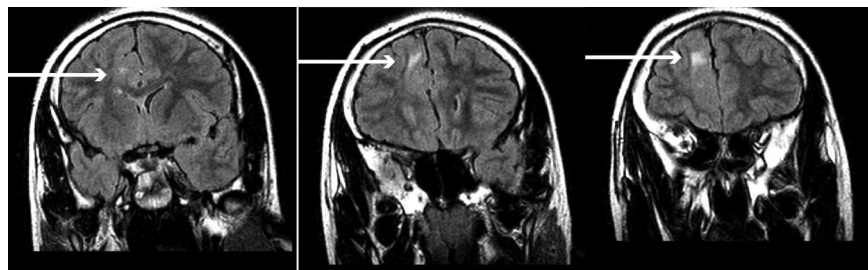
In the same patient as in figure 1, three sequential sections of a coronal fluid-attenuated inversion recovery MRI show a high-intensity lesion in the right cingulate gyrus, ipsilateral to cutaneous findings (arrows). Hypomelanosis of Ito (HI) lacks characteristic neuroimaging findings probably as the result of mosaicism and ranges among cortical dysplasias, heterotopias, and hamartomas.
